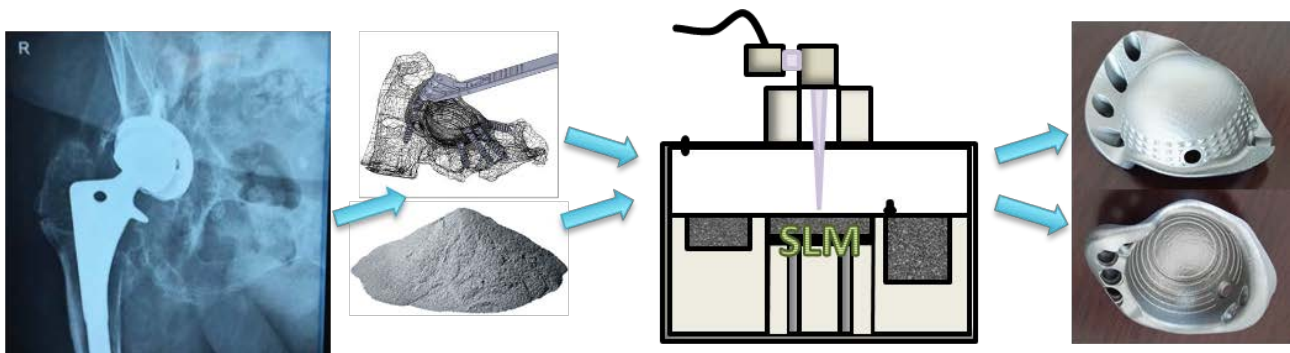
Patients who require custom implants can receive them through the combination of AM techniques and medical imaging. Generally, patient data (e.g. MRI or CT scans) is used to create the design of the part, this CAD file (in stereolithography format) is then sliced and otherwise manipulated such that the AM machine (SLM shown here) can fabricate the part. Following fabrication and some minor post-processing, the custom implant can be delivered to the patient, with a drastically reduced lead time.
